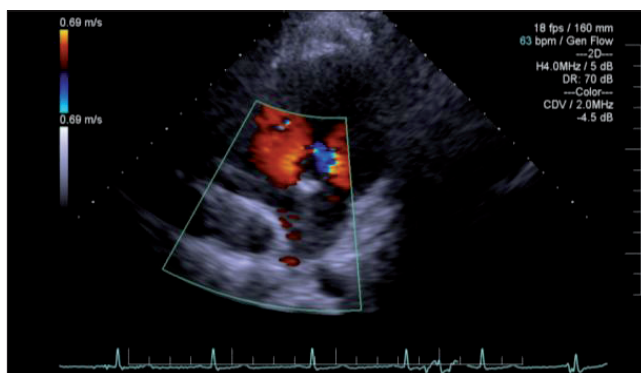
Echocardiography – four-chamber view.
